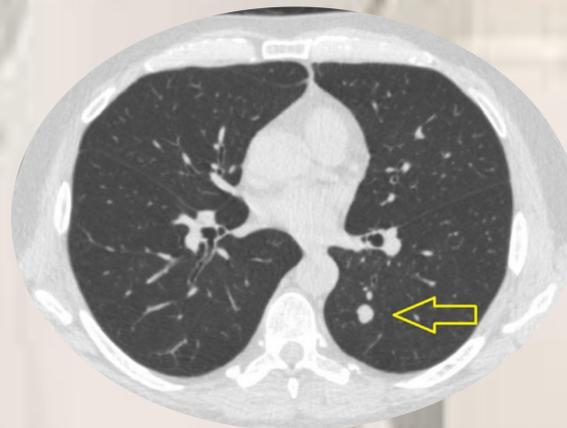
CT slice identifying detection of lung nodule (yellow arrow) derived from Ritchie et al (2016). [7]
